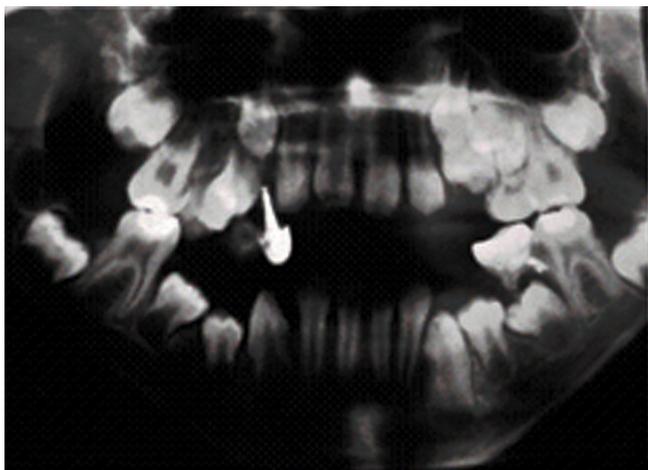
Hutchinson's teeth sign. Panoramic radiograph: presence of restorations in posterior teeth and absence of some deciduous teeth that it is not common to see in this patient's age [42]
